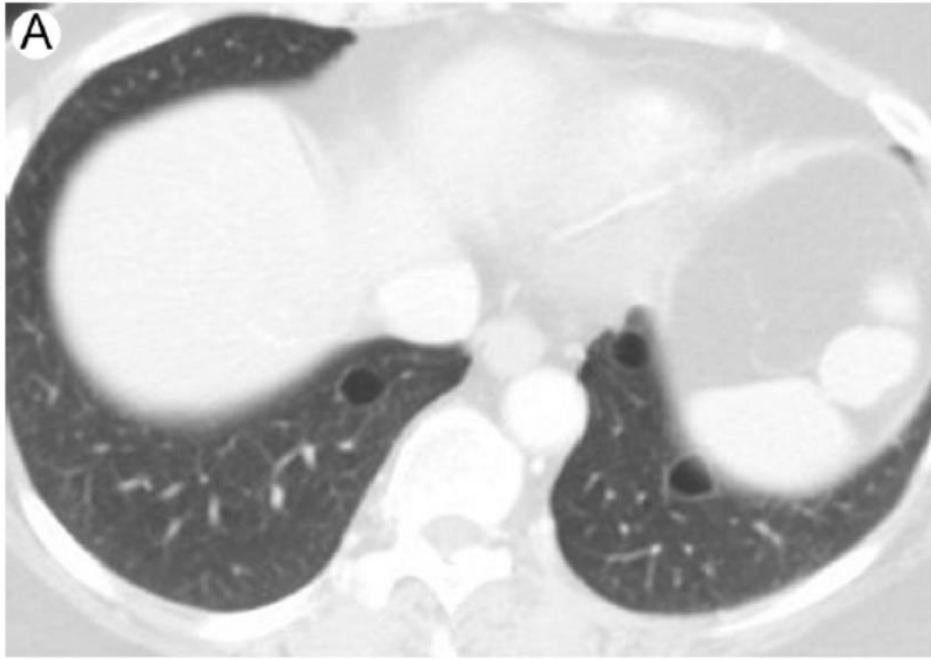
Lymphocytic interstitial pneumonitis in 69-year-old woman with systemic lupus erythematosus. Axial CT image reveals ground-glass opacity, interlobular septal thickening, and traction bronchiectasis associated with parenchymal cysts in the left lung.
